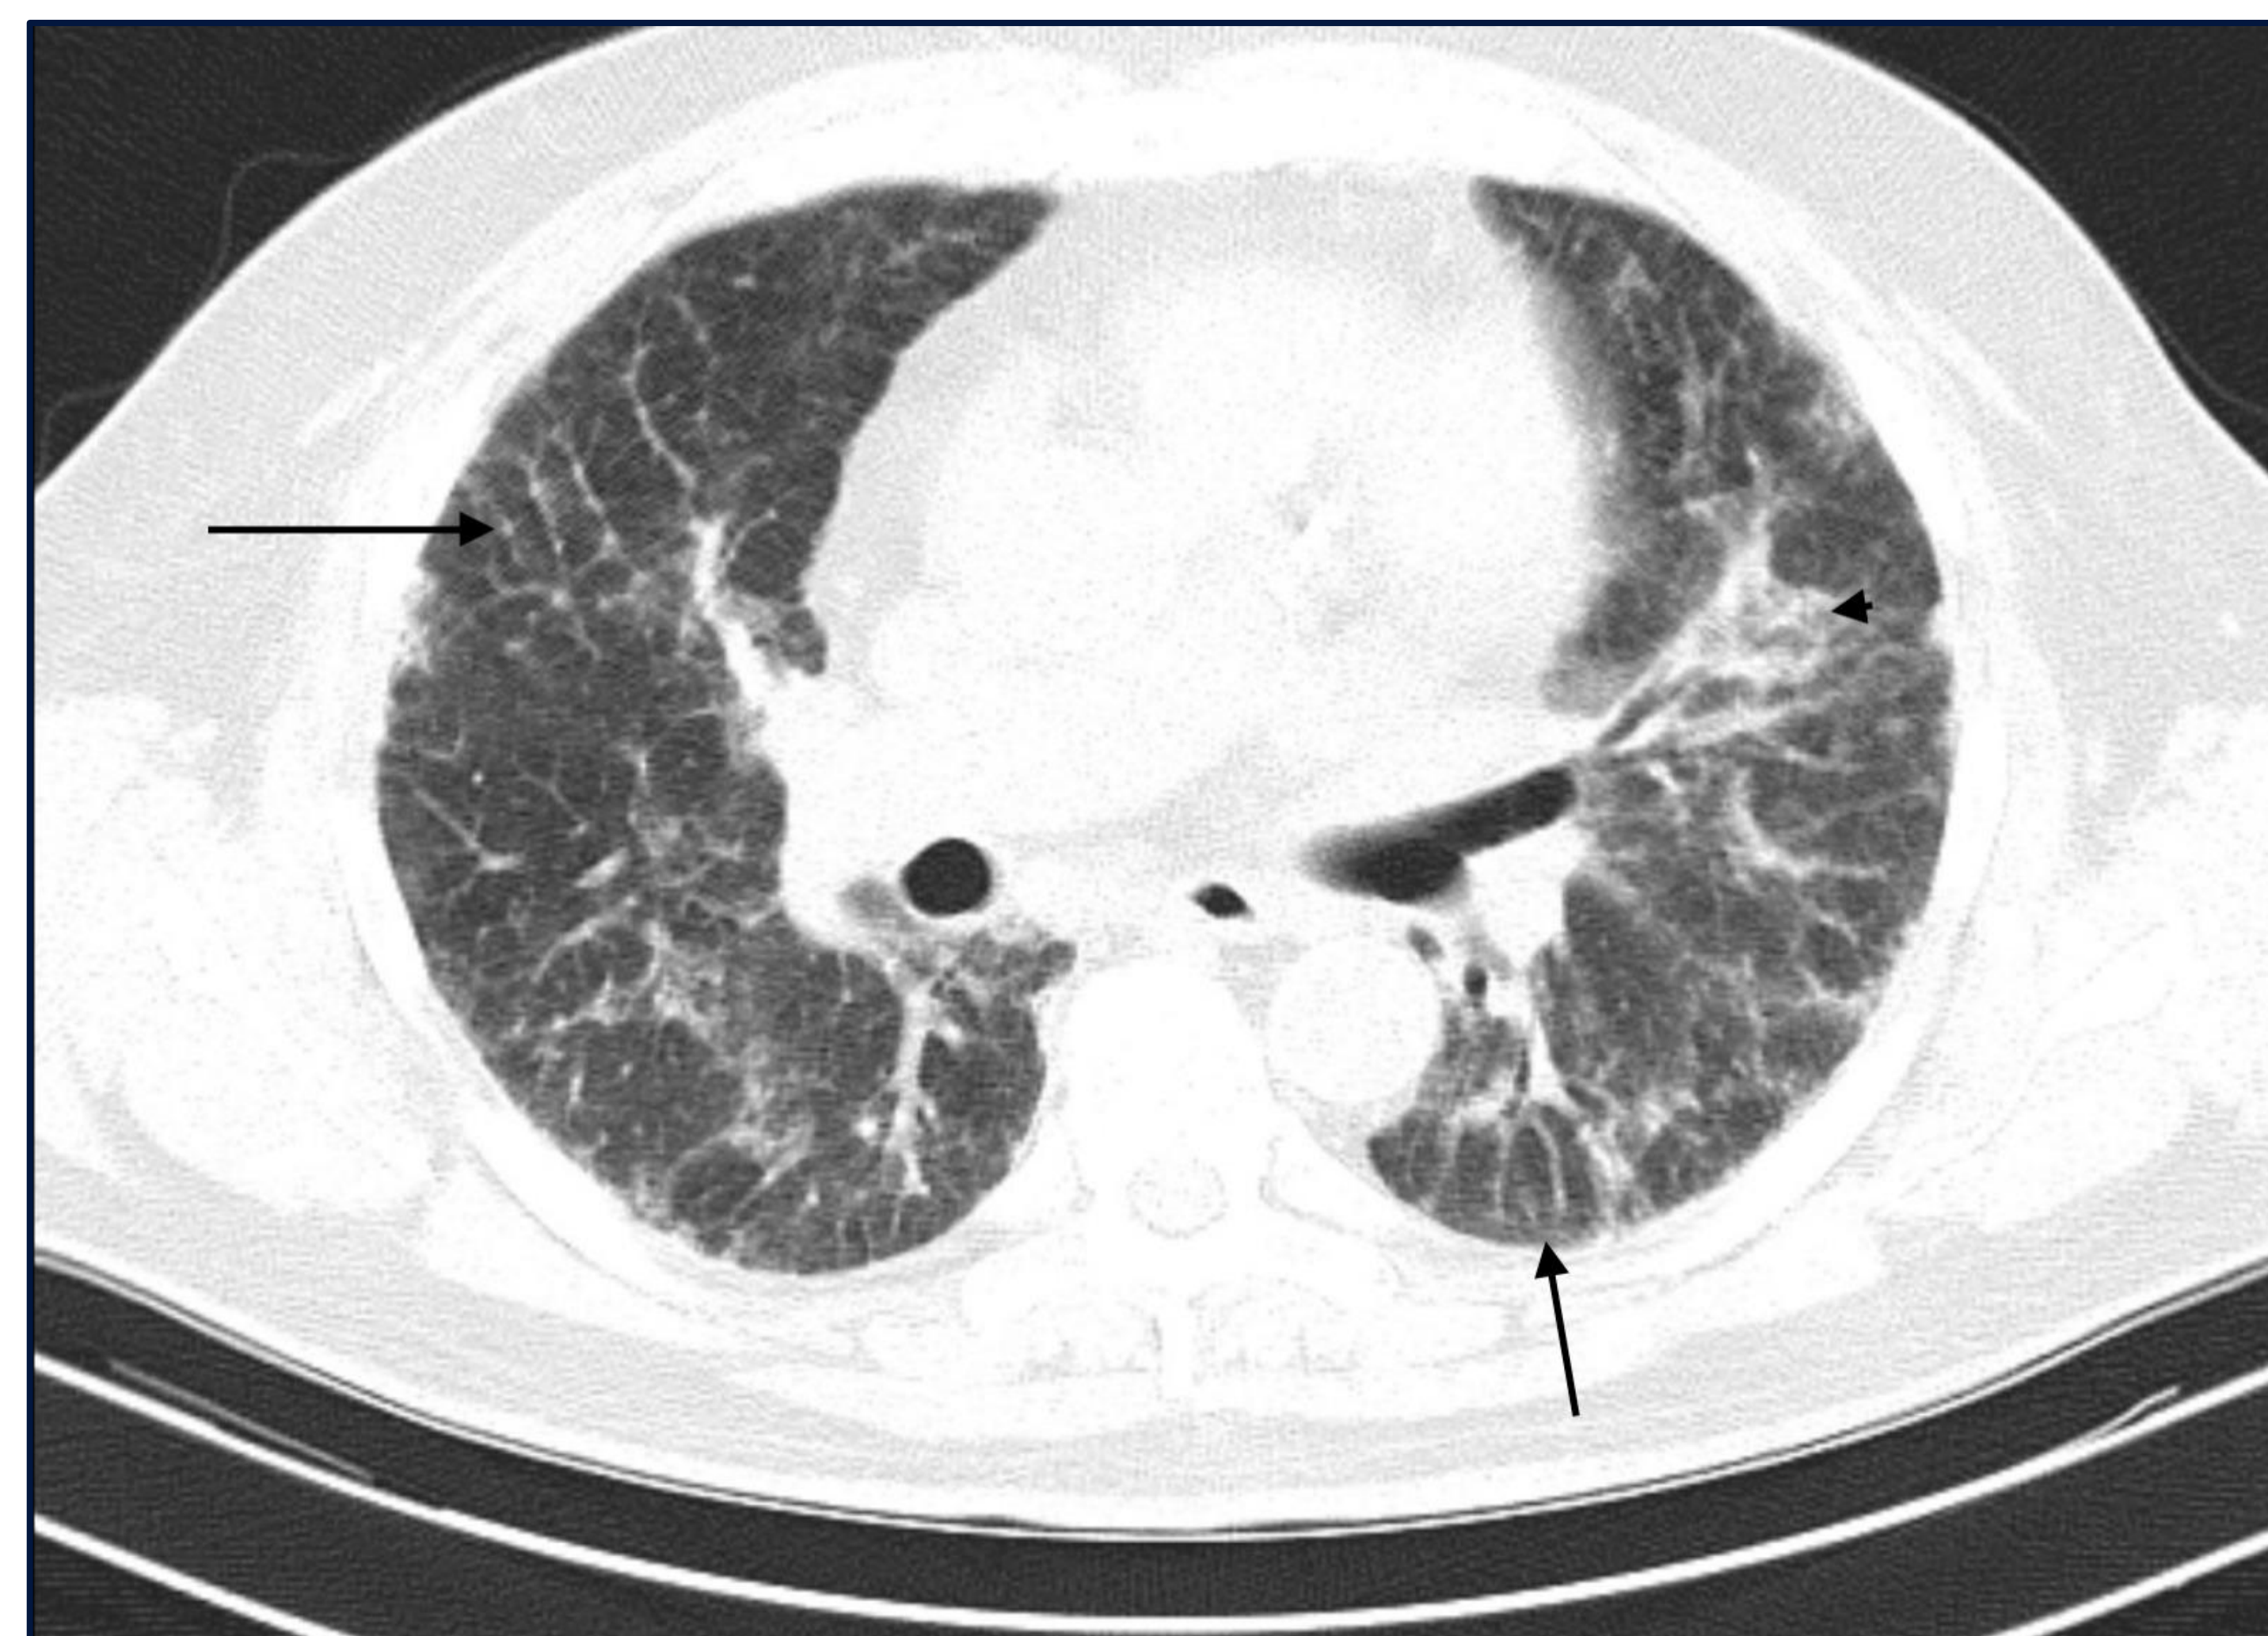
Chest high-resolution computed tomography showing, reticular fibrosis (arrows) also with ground glass opacities (arrow head)
